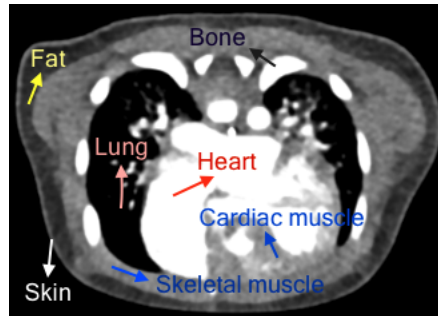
Six different tissue types: skin, fat, skeletal muscle and cardiac muscle, lung, heart and bone, indicated by arrows and texts, are shown in this CT image.
